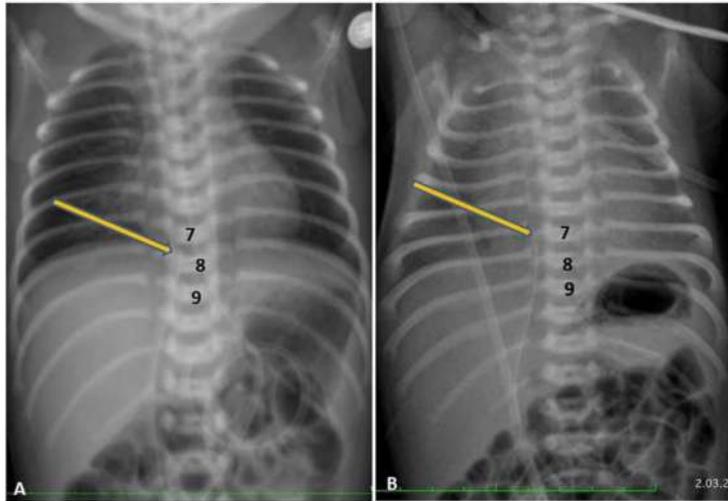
A) Normal radiographic appearance of the umbilical venous catheter (UVC). The tip of the umbilical venous catheter (arrow) ends at the thoracic 8 vertebra level. B) On the abdominal radiograph showing the abnormal position of the UVC, the tip of the catheter (arrow) is at the level of the T7 vertebra (possibly in the atrium).
